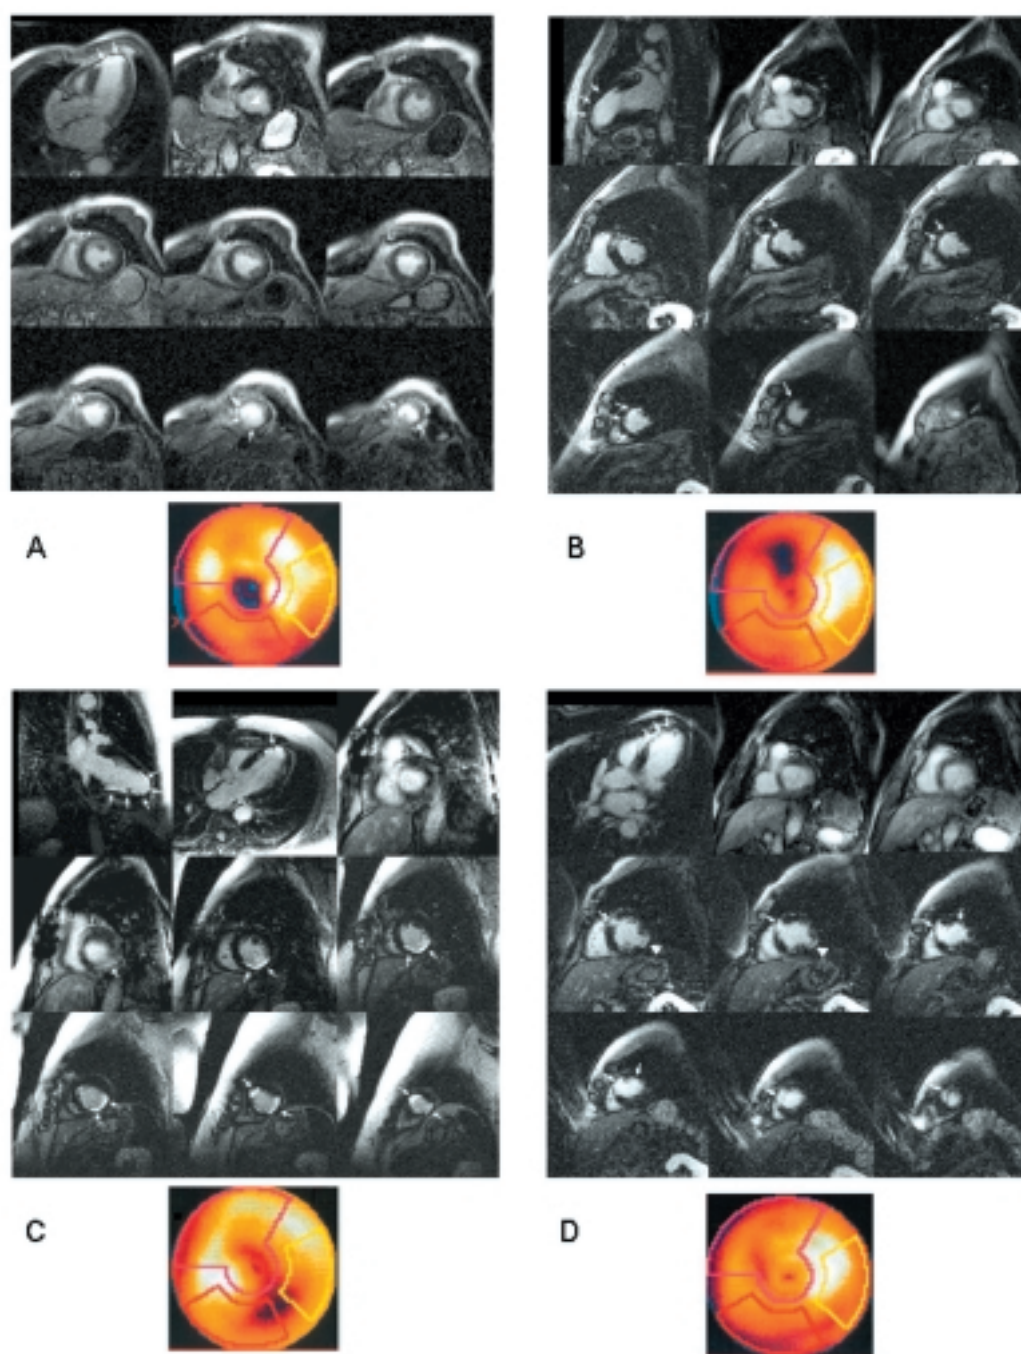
Examples of myocardial infarctions assessed as delayed enhancement at magnetic resonance imaging and as rest perfusion defect at single-photon emission computed tomography. In each panel magnetic resonance imaging long-axis views (more appropriate ones) and contiguous multiple short-axis views of the contrast-enhanced magnetic resonance imaging study (upper part) and color encoded bull's-eye display of single-photon emission computed tomography rest perfusion assessment (lower part) are shown. Panel A: small subendocardial scarring in the basal segment of the postero-lateral wall (arrow tip) and medium size transmural scarring involving the septal-apical and inferior-apical segments detected at contrast-enhanced magnetic resonance imaging (arrows) as well as at single-photon emission computed tomography. Panel B: medium size subendocardial scarring of the mid-anterior wall detected at contrast-enhanced magnetic resonance imaging (arrows) as well as at single-photon emission computed tomography. Panel C: large subendocardial scarring involving the mid-distal segment of the infero-lateral wall and the apical segments of the septum and lateral wall as seen at contrast-enhanced magnetic resonance imaging (arrows) as well as at single-photon emission computed tomography. Panel D: small subendocardial scarring in the mid-segment of the postero-lateral wall, as seen at contrast-enhanced magnetic resonance imaging (arrow tip) but not at single-photon emission computed tomography, and medium size scarring involving the mid-distal segment of the anterior septum as seen at contrast-enhanced magnetic resonance imaging (arrows) and at single-photon emission computed tomography. Mild perfusion defect in the basal segment of the inferior and infero-lateral walls at single-photon emission computed tomography without the related delayed enhancement at magnetic resonance imaging, suggesting attenuation.
